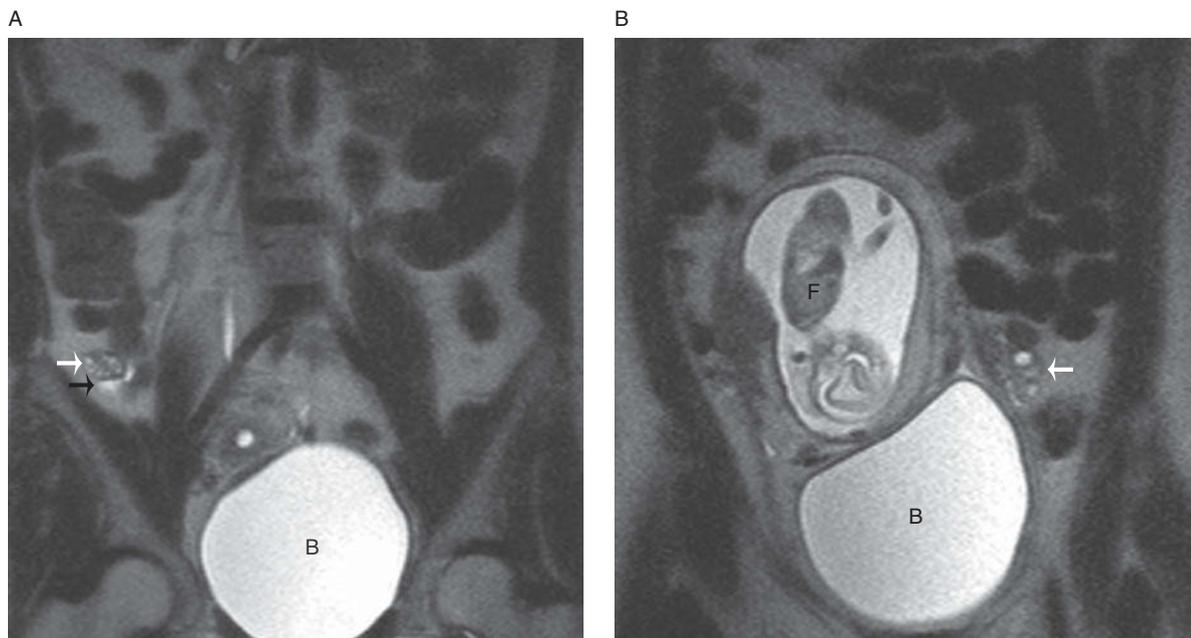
Normal ovaries in a 25-year-old pregnant female. Coronal T2-weighted image (A) demonstrates a normal right ovary (white arrow) with a small amount of physiologic free fluid (black arrow) adjacent to the ovary. More anterior coronal T2-weighted image (B) also demonstrates a normal left ovary (arrow) with subcentimeter follicles. Bladder (B). Also note gravid uterus with fetus (F).
